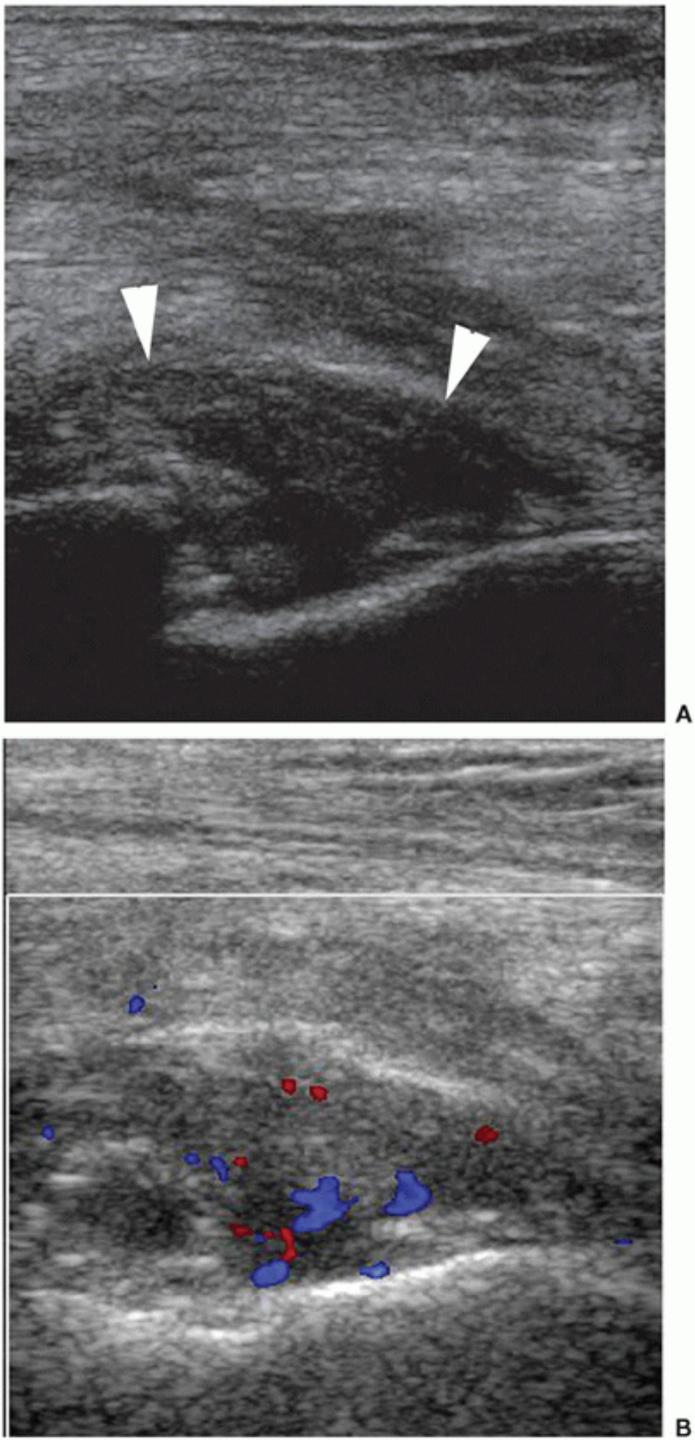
Infected Hip. Longitudinal sonogram shows (A) heterogeneous hypoechoic collection in a distended joint (arrowheads) and (B) Color Doppler demonstrates increased vascularity due to inflammation.
